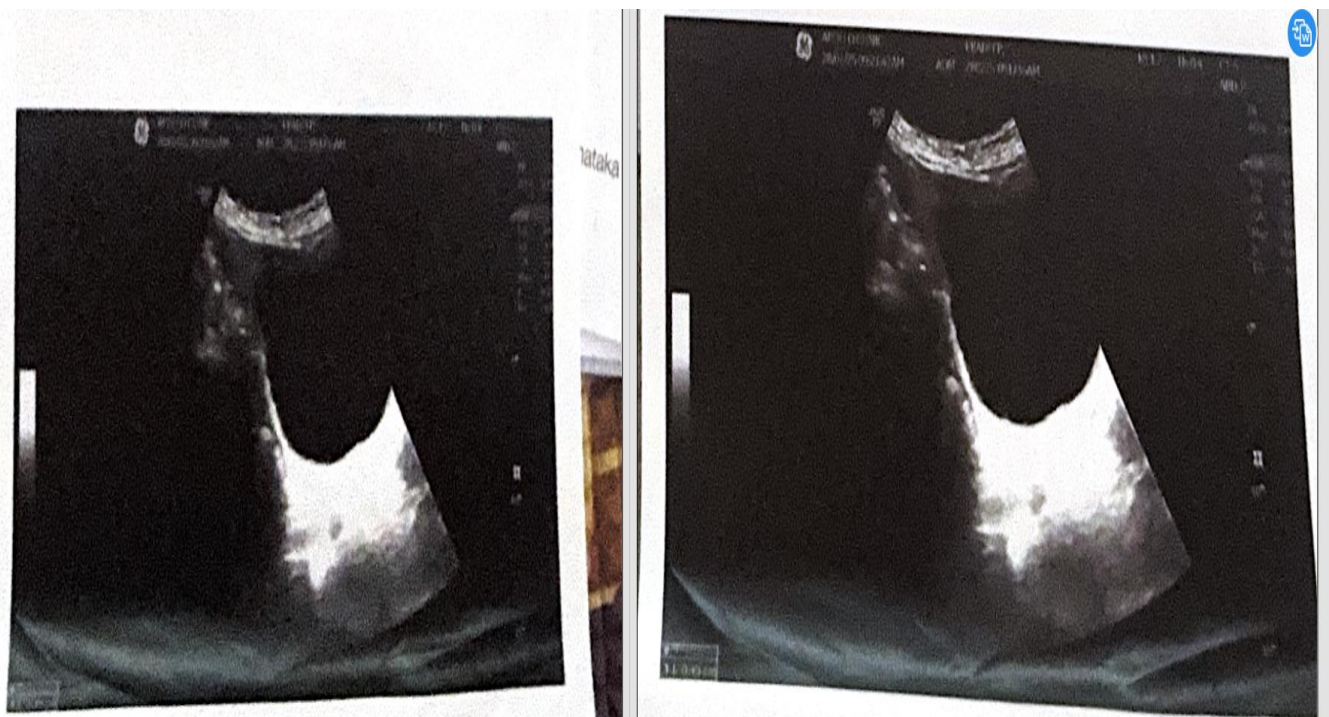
PRE AND POST VOID RESIDUAL URINE IN URINARY BLADDER ON ULTRASONOGRAPHY
